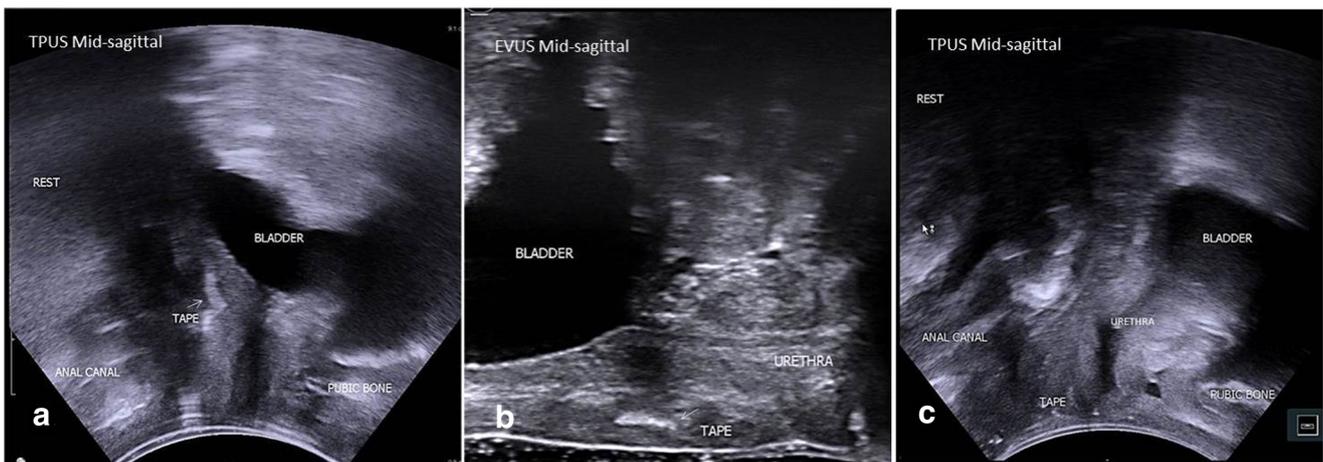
Position of the MUS relative to the urethral length. a Perineal ultrasound showing proximal placement of the MUS. Mid-sagittal section demonstrating a MUS placed too proximally as it can be seen by the bladder neck, this patient presented with persisting stress incontinence
